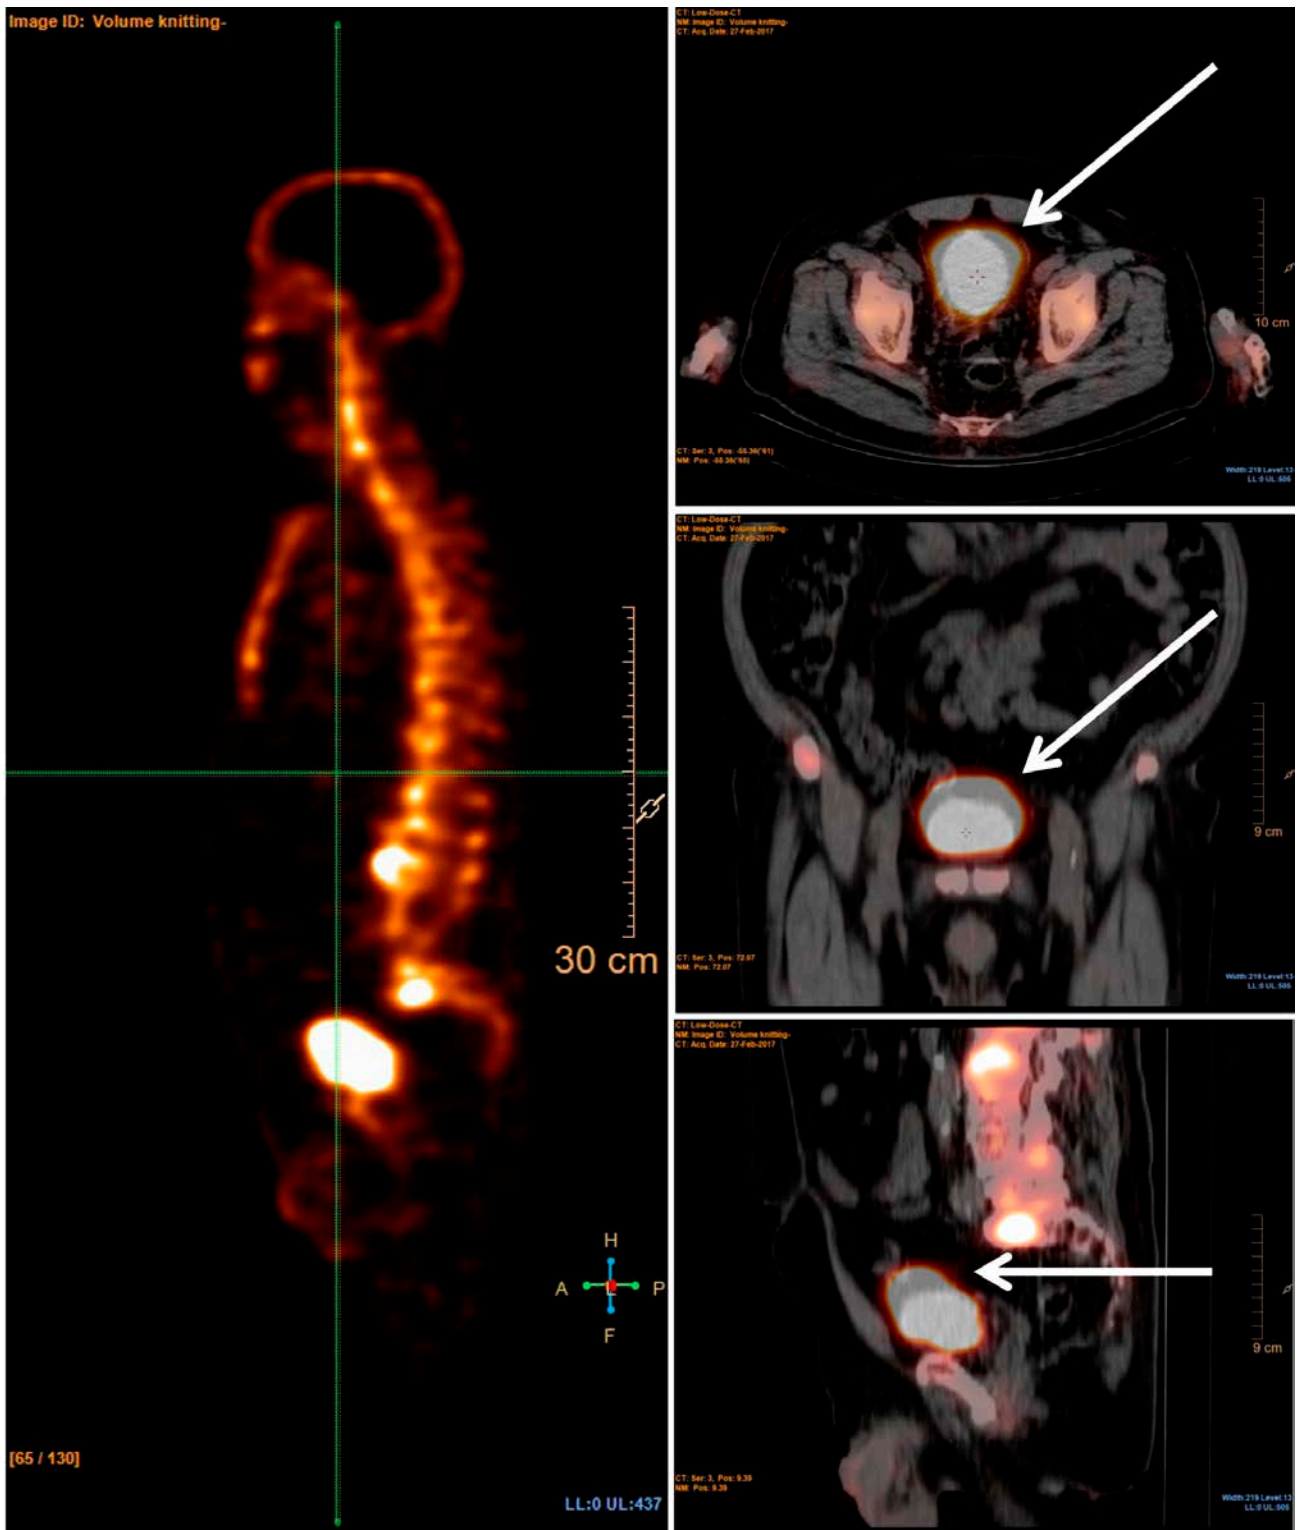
The time difference between CT and SPECT may cause the bladder to present with different degree of filling (arrows). This may potentially displace lesions, causing a mismatch.
